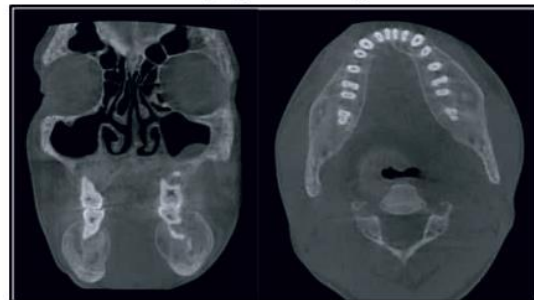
Coronal section of CBCT showing buccolingual expansion of mandible (left) & Axial section showing altered trabecular pattern (right)
